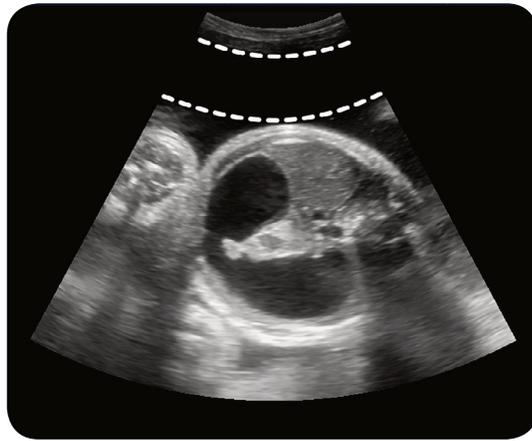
A fetal ultrasound scan demonstrating polyhydramnios. There is a large hypoechoic region between the fetus and the maternal abdominal wall. There is also the double-bubble sign of duodenal atresia, which is the underlying cause in this case.
